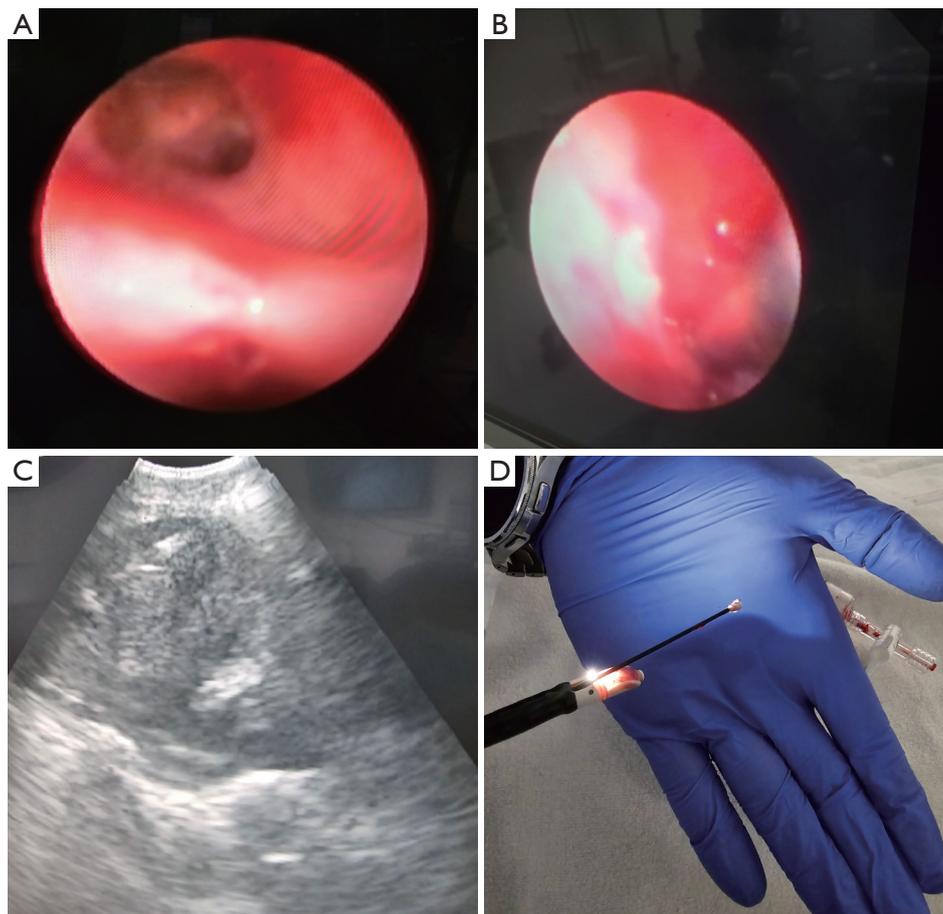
Execution of EBUS-guided lymph node cryobiopsy. (A) Bronchial view of mediastinal space puncture-site access after TBNA. (B) Cryoprobe entering the puncture site under direct visualization. (C) Direct visualization via EBUS of cryoprobe entering lymph node. (D) Frozen tissue surrounding the cryoprobe tip after the probe is removed *en-bloc*. These images are published with the patient's consent. EBUS, endobronchial ultrasound; TBNA, transbronchial needle aspiration.
